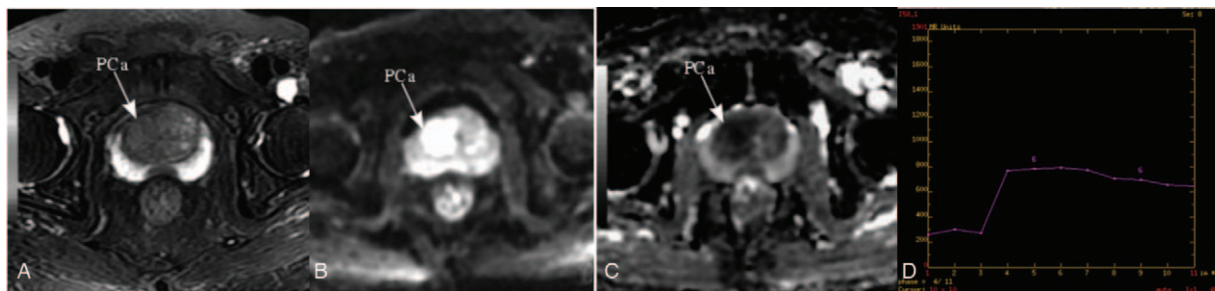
Magnetic resonance imaging examination of the central region of prostate cancer (PCa).
